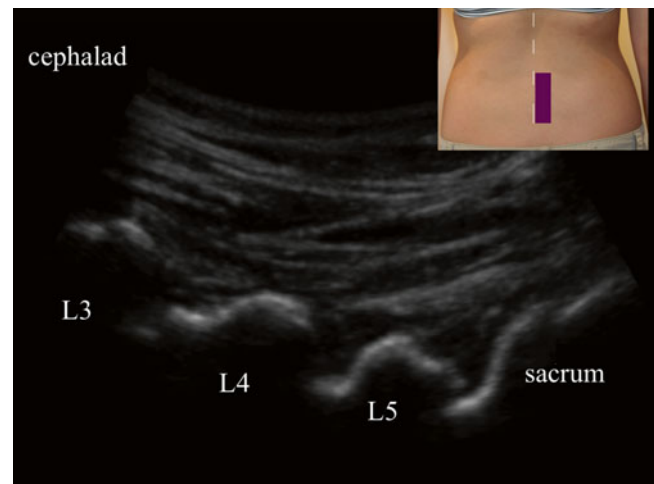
Ultrasound image of a paramedian view of the sacrum, L5, L4, and L3 from a longitudinal approach, forming a “sawtooth” pattern (Image courtesy of Agnes Stogicza, MD)
